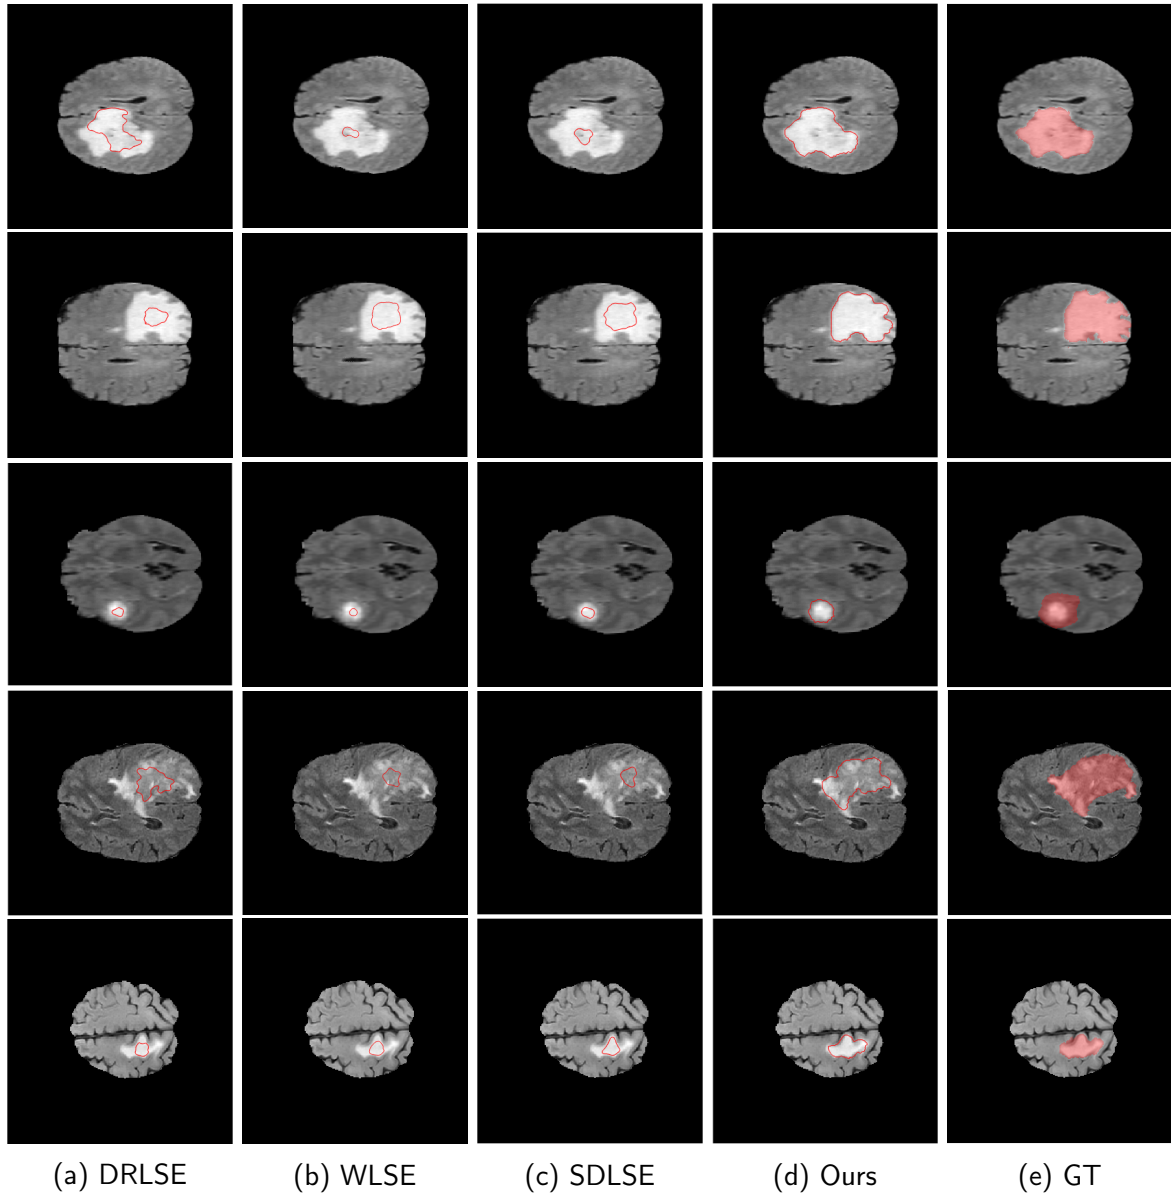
Segmentation of MRI Slices
